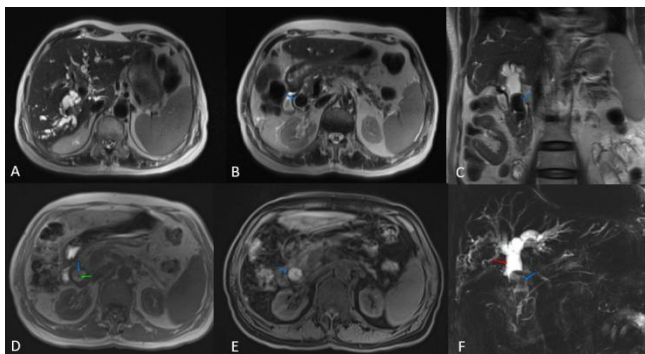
Axial (A, B) and Coronal (C) T2 weighted image of the MRI (magnetic resonance imaging) of the abdomen shows severe dilatation of the intrahepatic biliary radicles, hepatic ducts and the proximal common bile duct with oblong hypointense calculus (blue arrow) in the mid and distal common bile duct. Axial non-fat saturated (D) and fat saturated (E) T1 weighted sequences show hyperintense calculus (blue arrow) with a central hypointense stent (green arrow). MIP (maximum intensity projection) image (F) shows filling defect in the mid and distal common bile duct.
